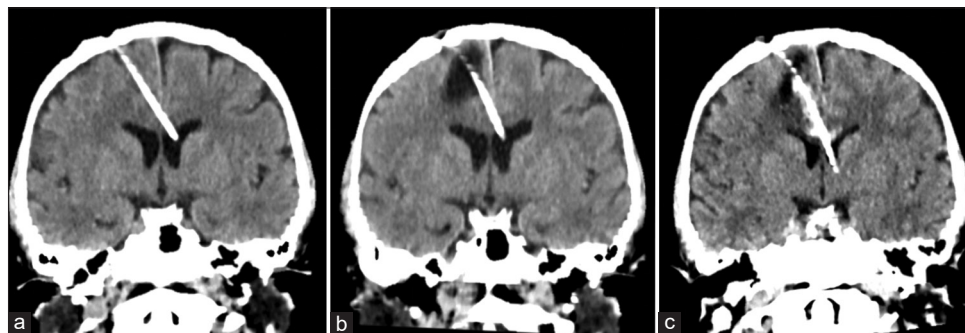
Imaging comparison. CT after VPS surgery: (a) coronal view demonstrating the catheter pathway without any parenchymal lesion. CT at revaluation (3 months later): (b) coronal view demonstrating the catheter pathway with an intraparenchymal pericatheter cyst and perilesional edema, without hydrocephalus. CT after shunt revision (postoperative): (c) coronal view demonstrating the new catheter pathway with cyst regression and mild intracystic hemorrhage.
